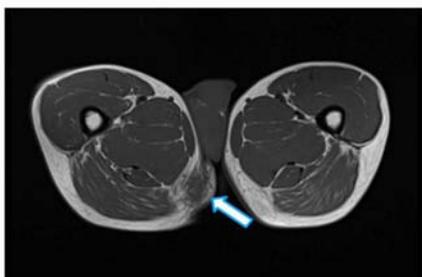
T1 weighted axial MRI image of the unilateral soft tissue benign perineal pseudotumor with ill defined margins and tissue edema in the right perineum.
